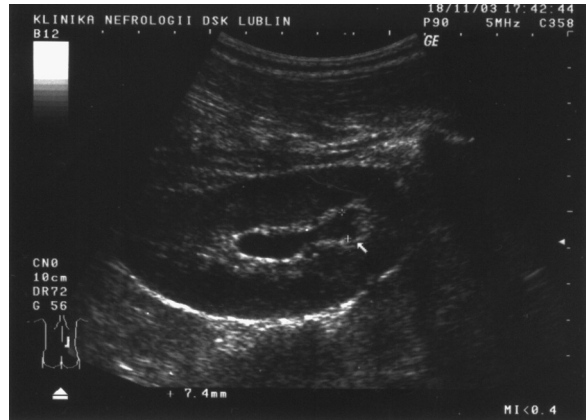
Isolated superior renal calyx with a diameter of 7 mm — longitudinal sonogram.
